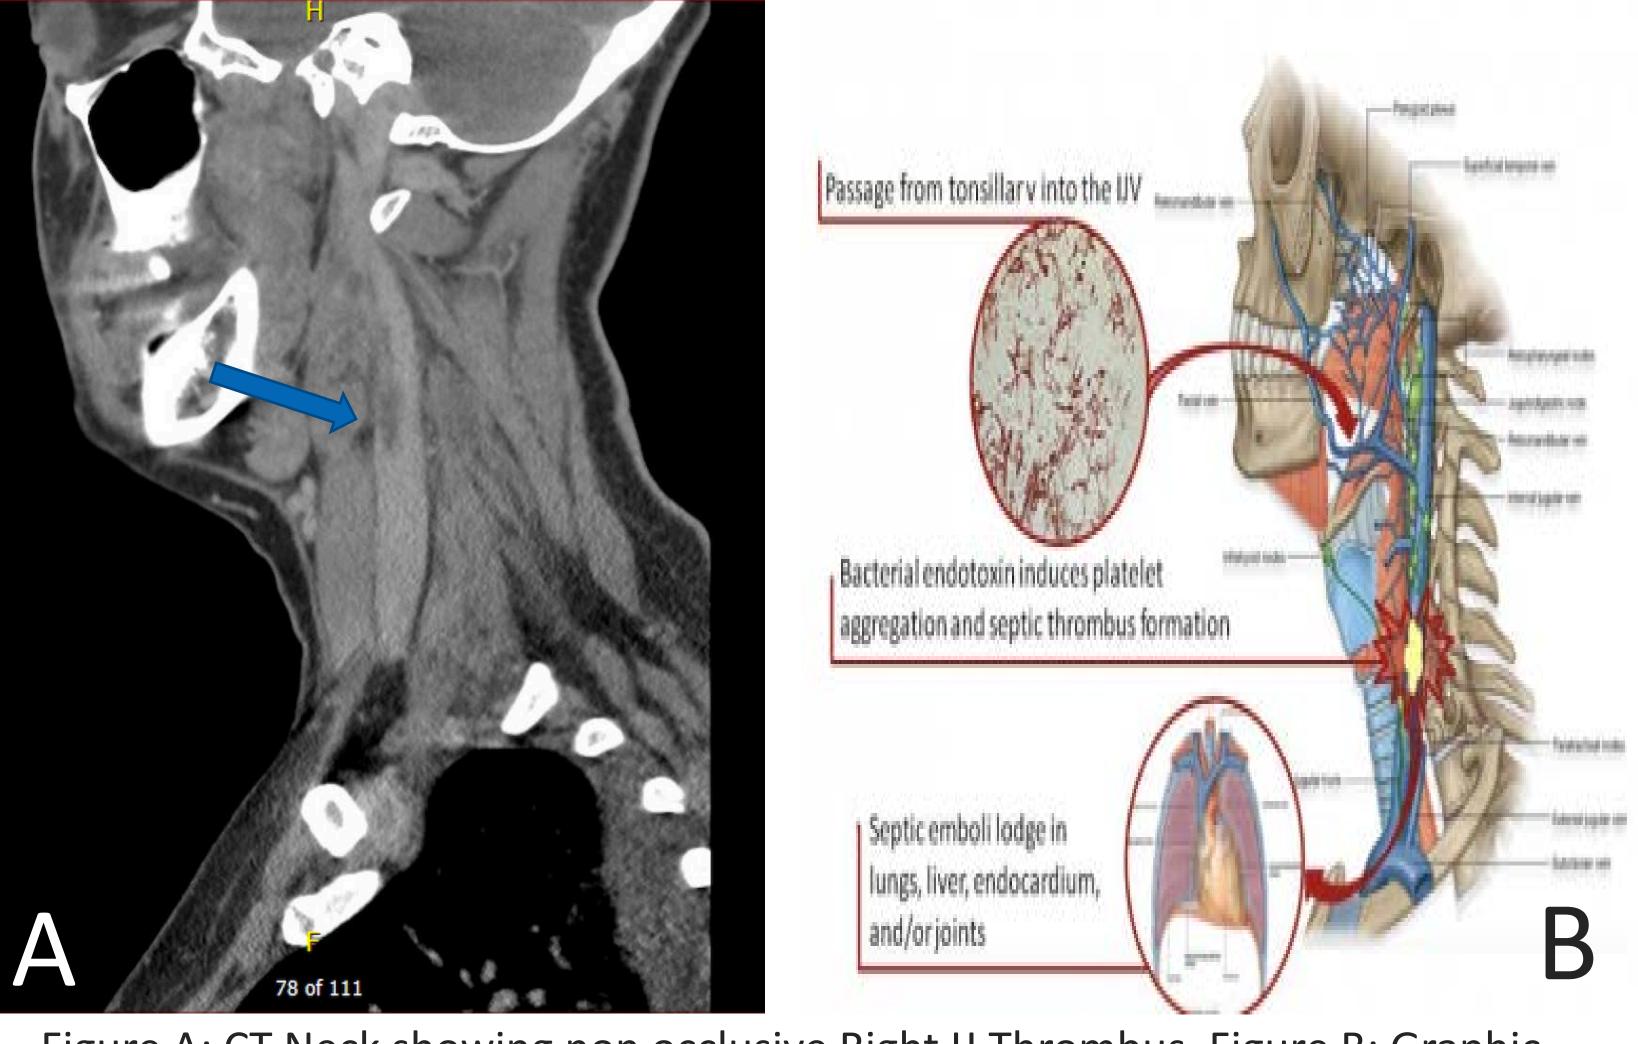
CT Neck showing non occlusive Right IJ Thrombus. Figure B: Graphic demonstrating pathogenesis of bacteria induced thrombus formation (4)
